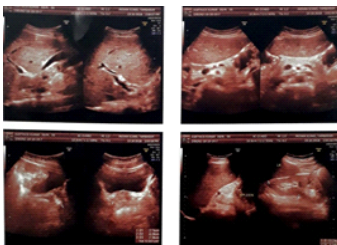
1 Ultrasound Abdomen Shows Hepatosplenomegaly
